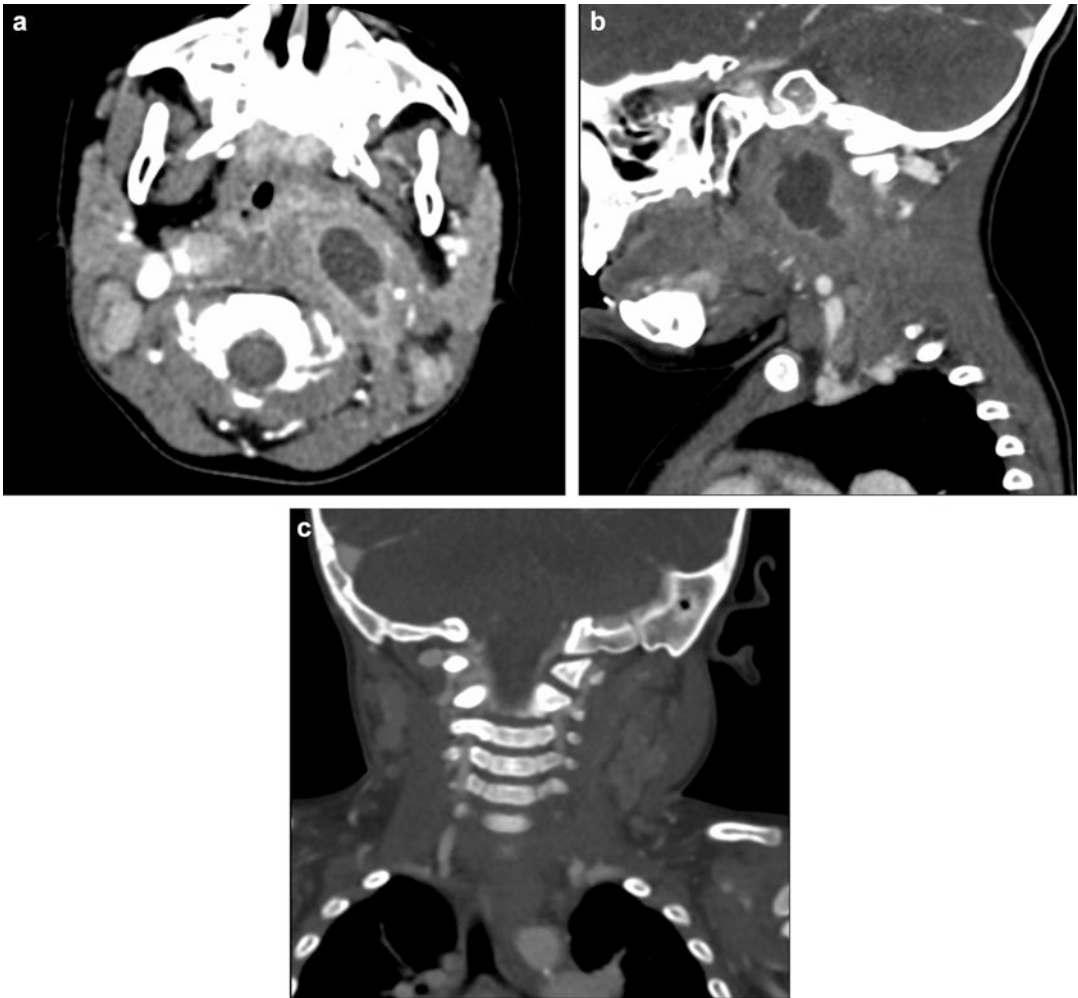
A 15-month-old male with fever, neck pain, swelling, and torticollis. (a, b) Axial and sagittal images from contrast-enhanced CT neck demonstrate a rim enhancing collection in the left retropharyngeal soft
